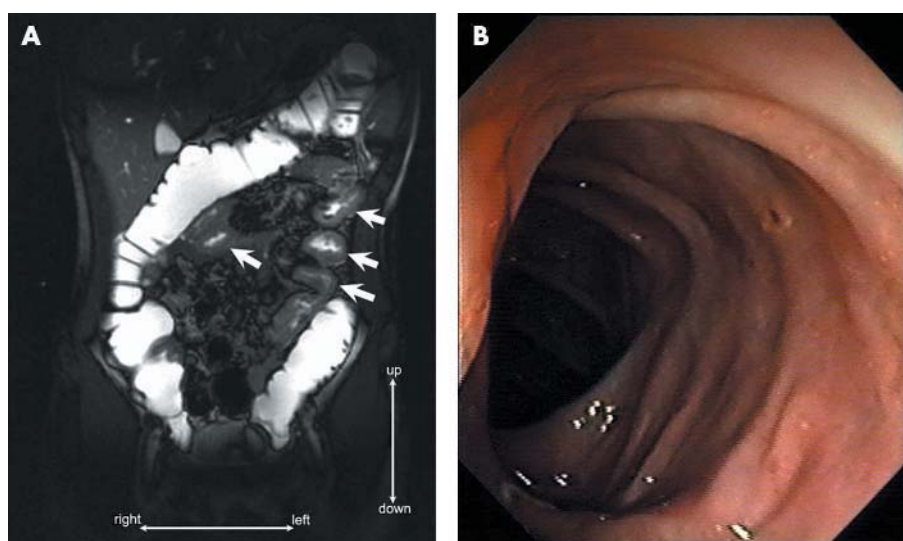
(A) Patient with Crohn's disease (CD) (patient No 20) and typical skip lesions (arrows) of the jejunum. The colon, which had a mild inflammation endoscopically, had a normal appearance on magnetic resonance imaging colonography. (B) Conventional colonoscopy of the same patient with CD revealed mucosal erythema and several small ulcers in the sigmoid colon (representative of similar findings in the rest of the colon of patient No 20).
